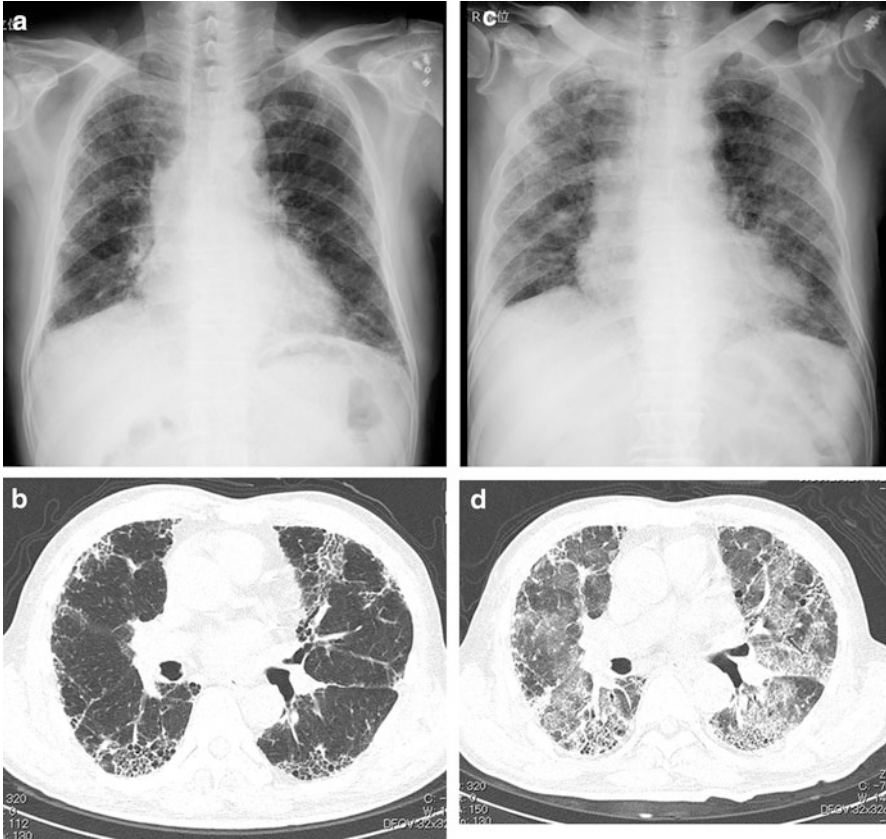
Acute exacerbation of IPF/UIP. (a) Chest x-ray shows volume loss in bilateral lungs with reticular opacity. (b) High-resolution computed tomography (HRCT) shows reticular opacity located predominantly in the subpleural region of lung base. (c) Chest x-ray at the onset of acute exacerbation shows widespread overlapping ground-glass opacity on pre-existing interstitial opacity. (d) HRCT shows widespread ground-glass opacity overlapping pre-existing interstitial pneumonia
